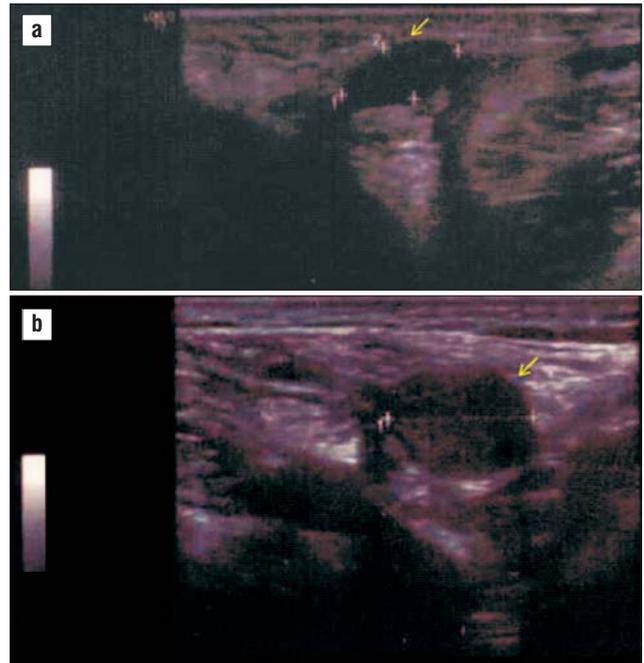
Testicular ultrasound showing bilateral remnants at the level of scrotum, suggestive for testicular regression syndrome: right testicle of 1 cm, respectively left testicle of 1.24 cm (arrow)
